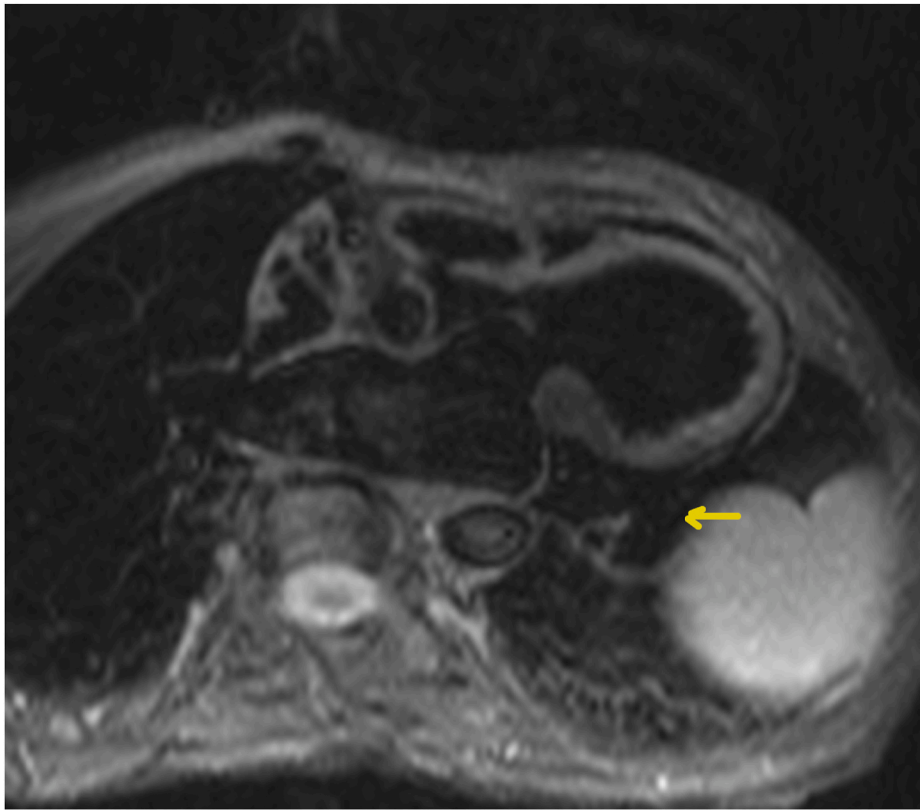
Axial MRI with injection of the gadolinium of LAAA.
